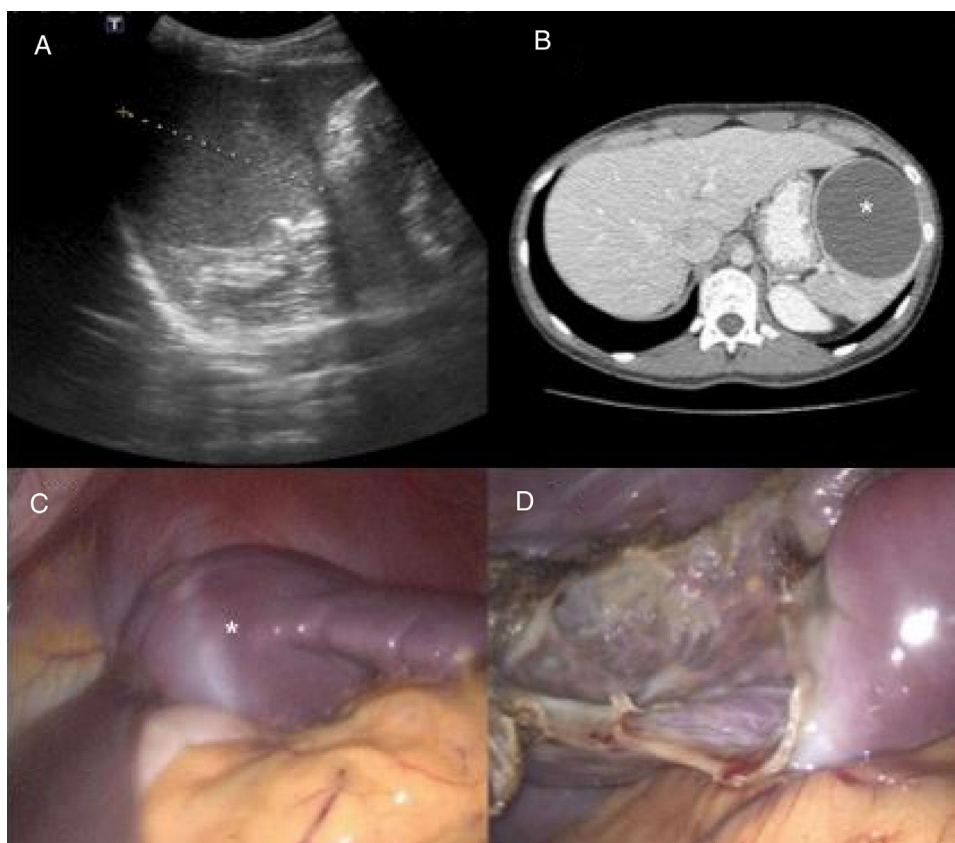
A) Preoperative abdominal ultrasound: splenic lesion measuring 7 cm in diameter with little acoustic enhancement and well-defined contours. B) Preoperative computed tomography scan: well-defined oval-shaped lesion consistent with a cyst of the spleen (asterisk). Note the displacement of the stomach. C) Laparoscopic intraoperative image: splenic cyst (asterisk) compressing the stomach before fenestration. D) Laparoscopic intraoperative image: remnant of the splenic parenchyma after fenestration.
